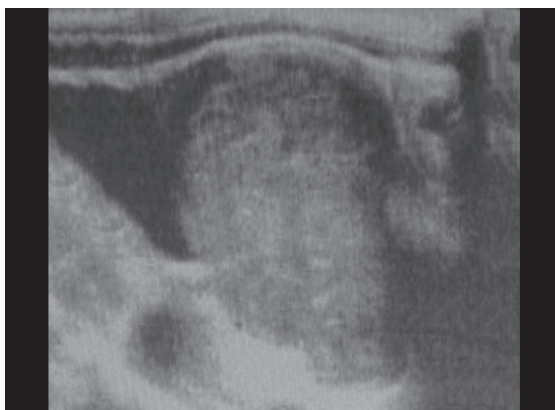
Ultrasound showing a lesion of substantial neoplasm, about 3.3 × 2.2 cm
